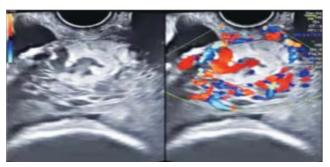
Colour doppler USG showing multiple vascular lacunae
